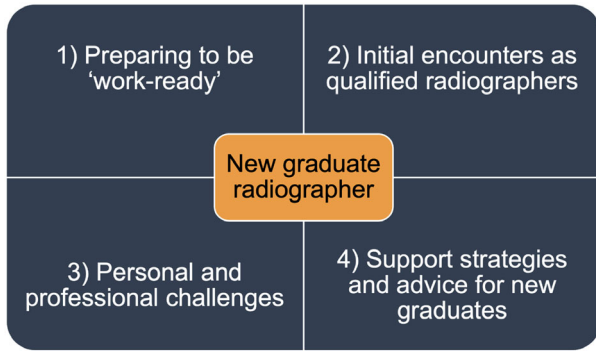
Major themes that emerged from exploring Australian graduate radiographers' perspectives and experiences of work readiness.
